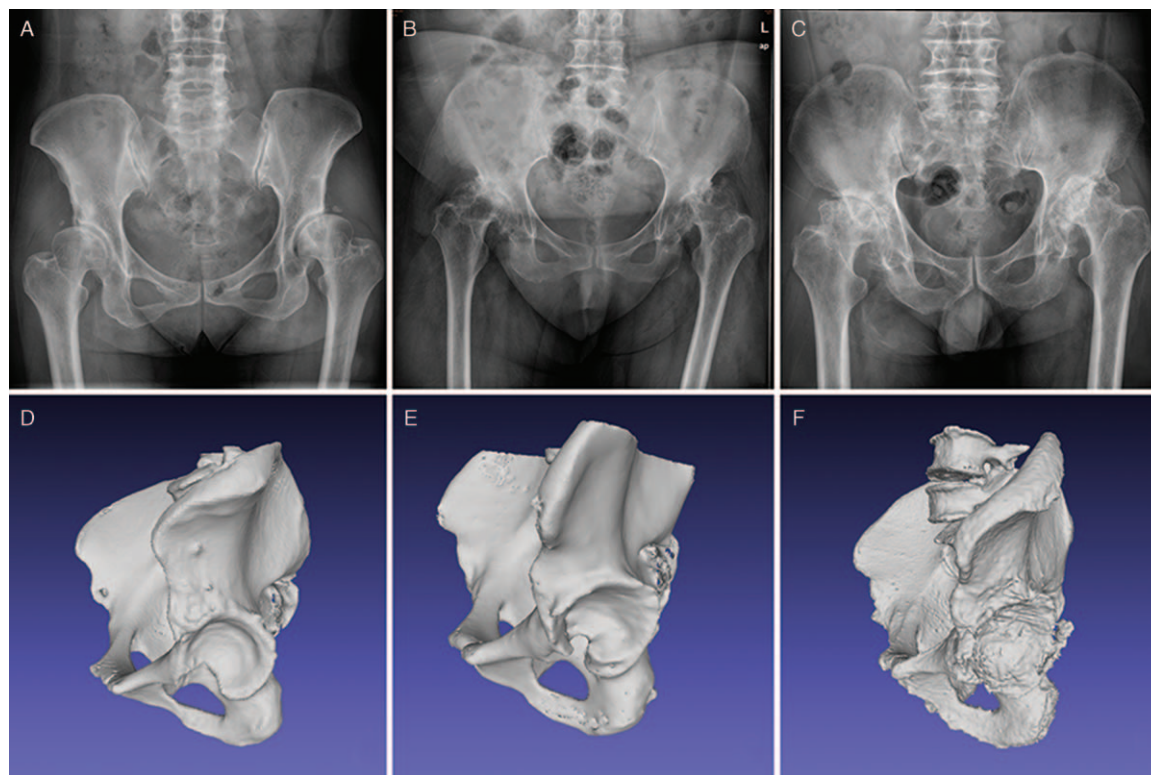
Plain radiograph and 3-dimensional reconstruction of Crowe types I to III dysplastic hips. (A, D) show Crowe type I hips, (B, E) show Crowe type II hips, and (C, F) show Crowe type III hips.
